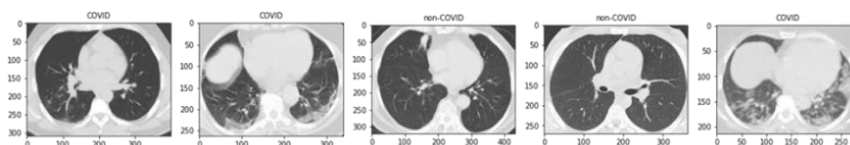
Samples of CT-scan images
